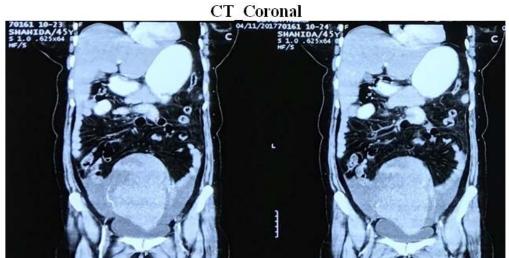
CT scan - Coronal
